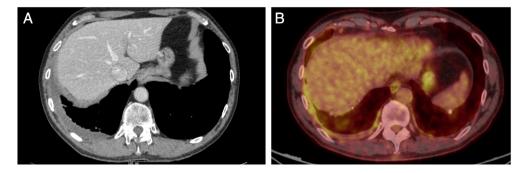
(A) Contrast-enhanced computed tomography (CT) showing a minimal amount of pleural fluid and pleural thickening but no other lesions. (B) Positron emission tomography-CT showing increased metabolic activity in the thickened pleura.
